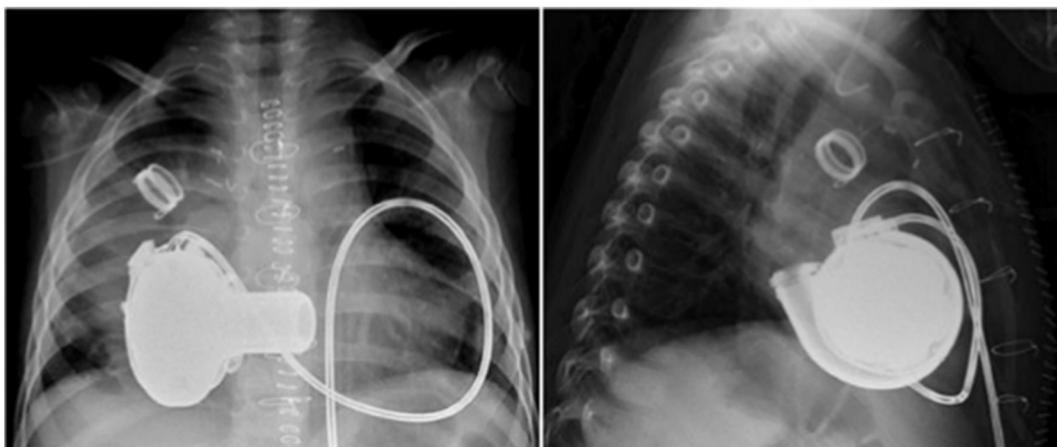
Creative strategies for VAD implantation: A chest radiograph of a 3.7 kg child with Fontan physiology after implantation of a continuous flow VAD in the common atrium with simultaneous excision of the AV valve. Nandi D, et al. *Ann Thorac Surg.* 2018
